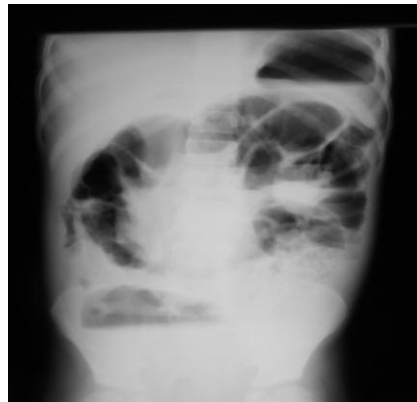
Erect abdominal radiograph of a 6 year old boy who presented with ruptured appendicitis.
